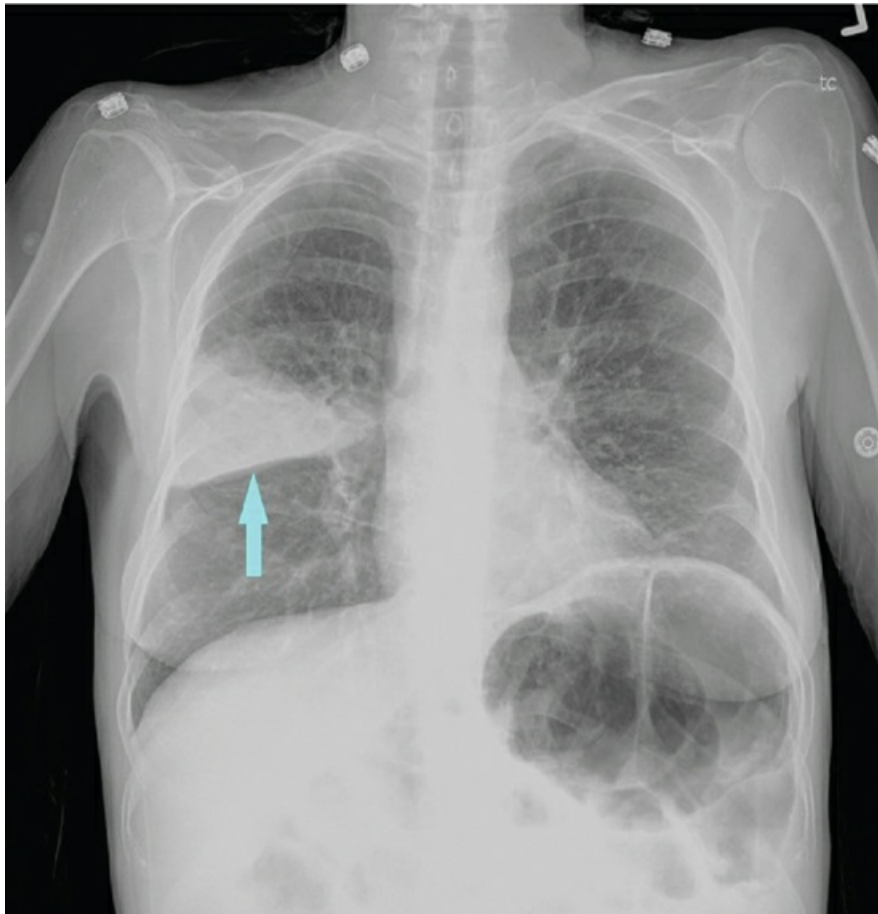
Posteroanterior chest radiograph shows homogeneous consolidation from a lobar pneumonia (probably caused by *Streptococcus pneumoniae*) affecting part of the right upper lobe. The arrow points to the minor (horizontal) fissure separating the right upper lobe from the right middle lobe. Also seen is a significant amount of air in the colon. *Source:* (Courtesy of Dr. Laura Avery.)
